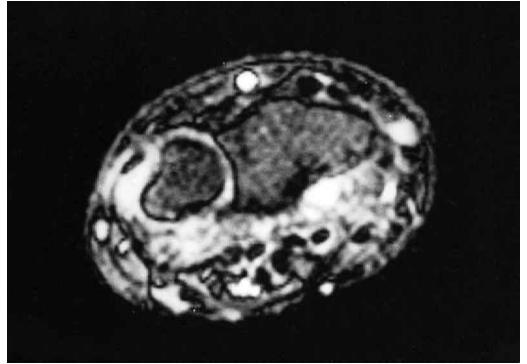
Case 1. Axial T2 MRI reveals high-signal intensity in the palmar aspect (synovial hypertrophy) and synovial fluid.
